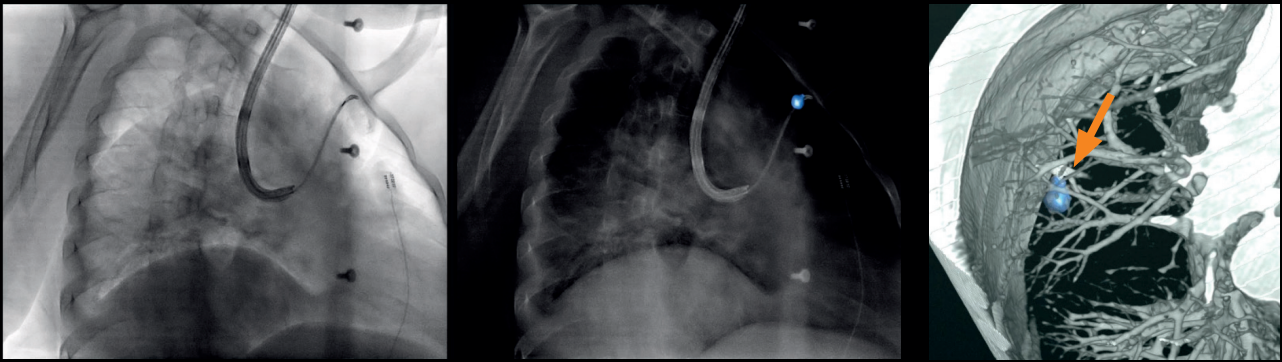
Endobronchial fiducial marker placement: Standard 2D live fluoroscopy versus corresponding augmented live fluoroscopy for navigating to the lesion (left and middle). Cone beam CT scan to confirm the position and provide definite and detailed anatomical information about lesion location with respect to the fiducial (right, highlighted).
